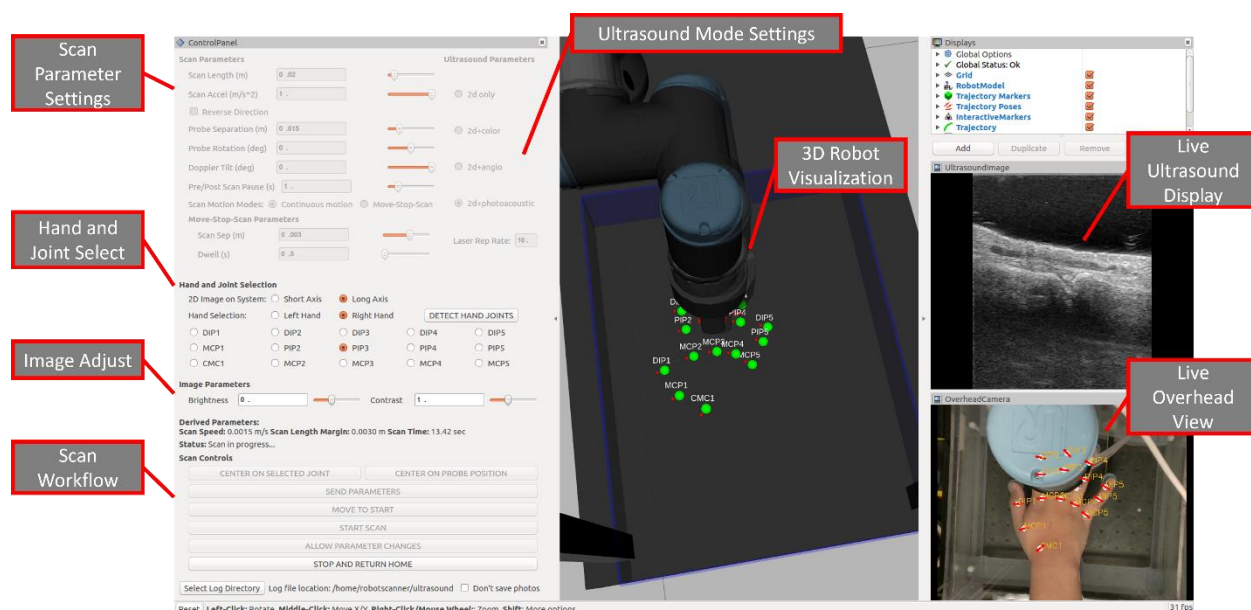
The user interface for the automatic 3D PA and US scanning system. The live ultrasound display and live overhead view are updated in real time. The 3D robot visualization moves with the scan. The detected hand joint locations are visible.
